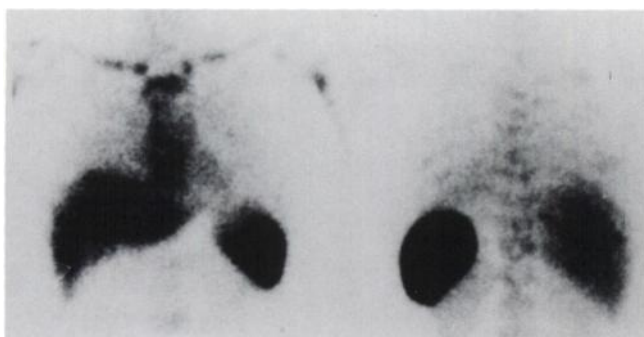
Initial bone marrow scintigram obtained 3 hr postinjection of ^{99m}Tc -labeled BW 250/183 demonstrates minimal tracer uptake in the axial skeleton, reflecting the destruction of the hematopoietic tissue, peripheral marrow expansion in the upper arms and increased liver and spleen uptake, probably due to extramedullary hematopoiesis, which does not obscure the thoraco-lumbar spine.
